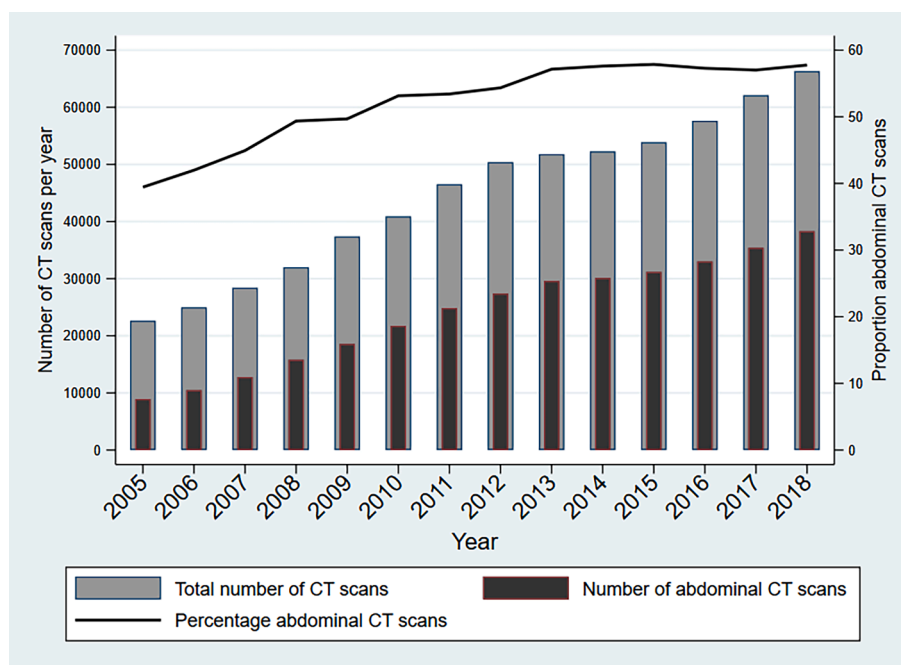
Numbers of abdominal CT scans in comparison to all CT scans from 2005 to 2018 in the North Denmark Region.
